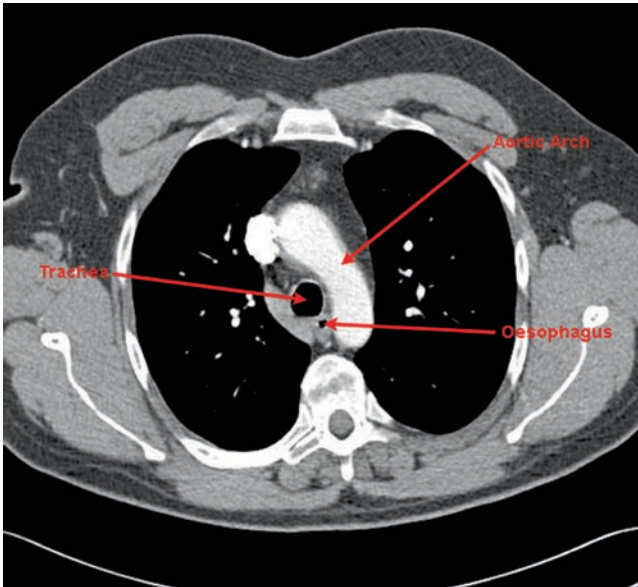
Thoracic CT slice taken at the level of T4 showing the relationship of the esophagus to the trachea and aortic arch.
